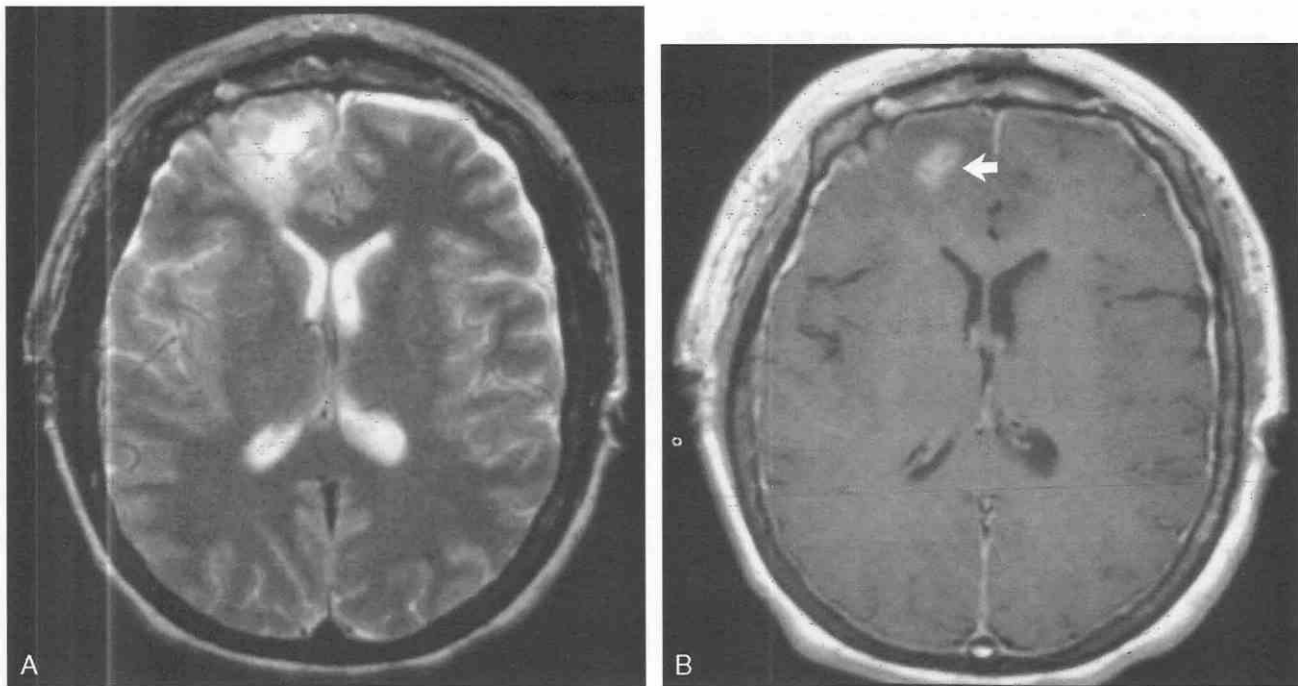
A, Cerebritis. Axial T2-weighted image (TR = 2500 msec, TE = 80 msec) shows edema in the right frontal lobe. Small, bilateral, convexity subdural hematomas are present. B, Contrast-enhanced T1-weighted image (TR = 500 msec, TE = 15 msec) reveals focus of nodular enhancement (arrow).
